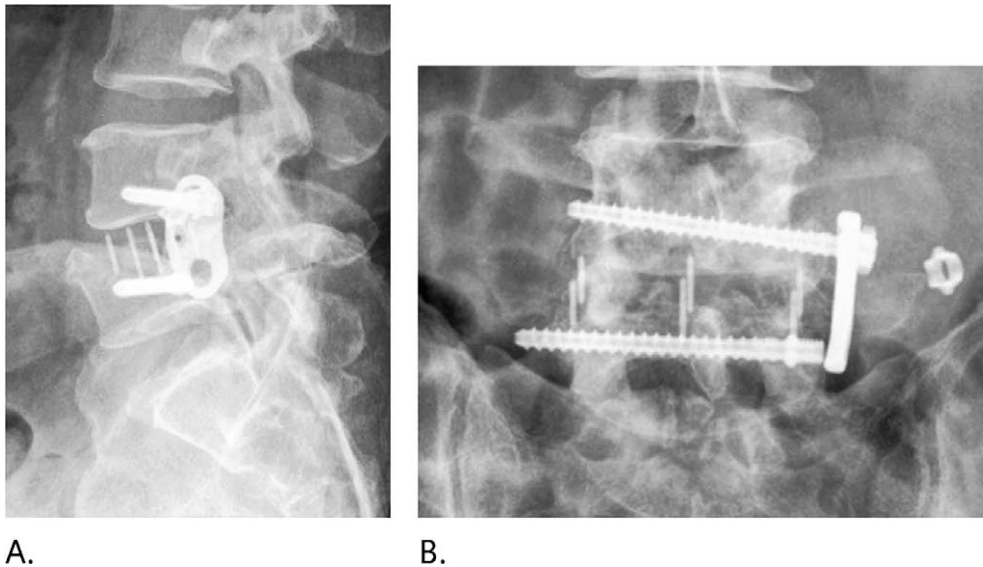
Lateral (A) and anteroposterior (B) x-rays at 2 weeks postoperatively showing the caudal screw dislodged from the plate and migrated through the L5 vertebral body and partially into the opposite psoas muscle.
